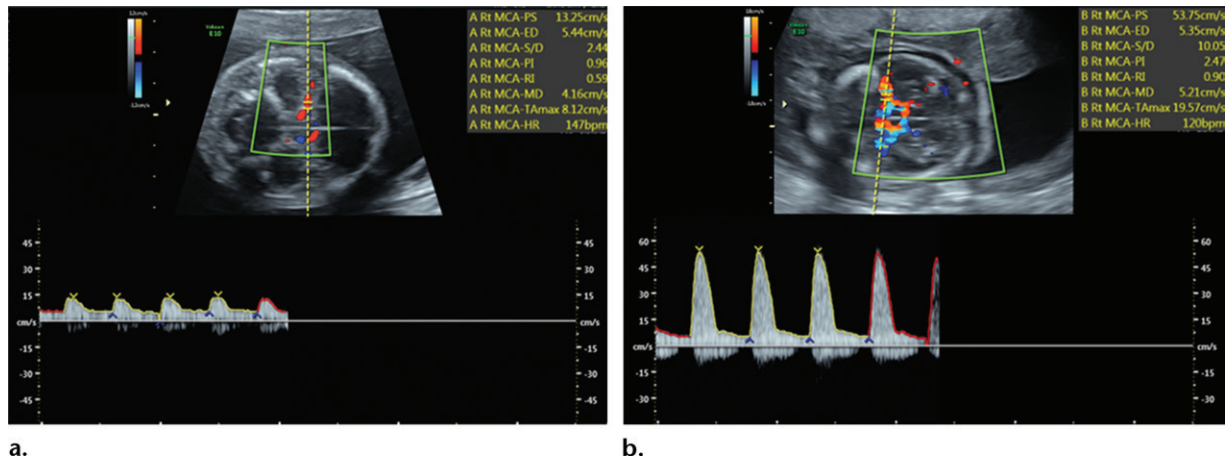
Pulsed duplex US images of the MCA at an axial section of the fetal brain performed for the evaluation of fetal anemia. (a) Pulsed color Doppler US image of a fetus at 20 weeks 2 days gestation shows a normal spectral waveform. The multiple of the median (MoM) was 0.51. (b) Pulsed color Doppler US image of a fetus at 21 weeks 6 days gestation shows an abnormal spectral waveform with an elevated PSV. The MoM was 1.93.
